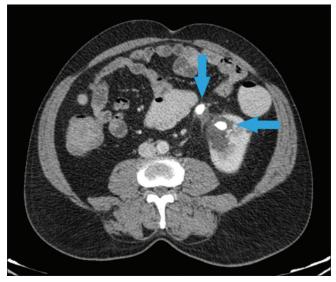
Contrast-enhanced computed tomography (CECT) scan of abdomen axial view showing stones in lower calyx of left kidney (horizontal arrow) and left pelvi-ureteric junction (vertical arrow)
